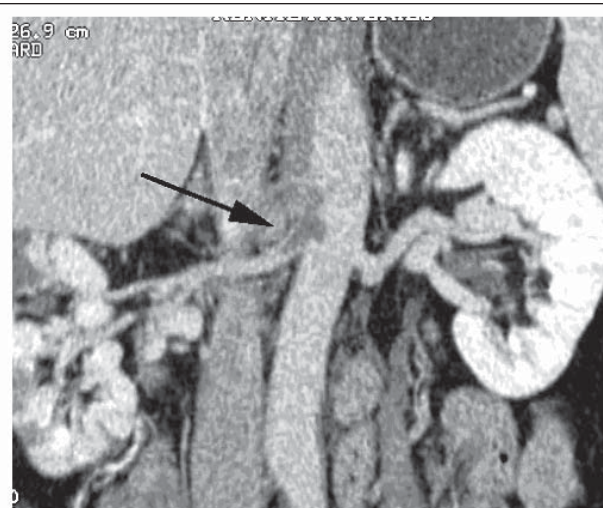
Coronal plane reformation of routine abdominal CT scan. Thrombus attached to right lateral wall of suprarenal aorta and projecting into proximal right renal artery is seen (black arrow). Note relative decreased enhancement of right kidney and multifocal peripheral zones of absent enhancement consistent with multifocal infarction.
